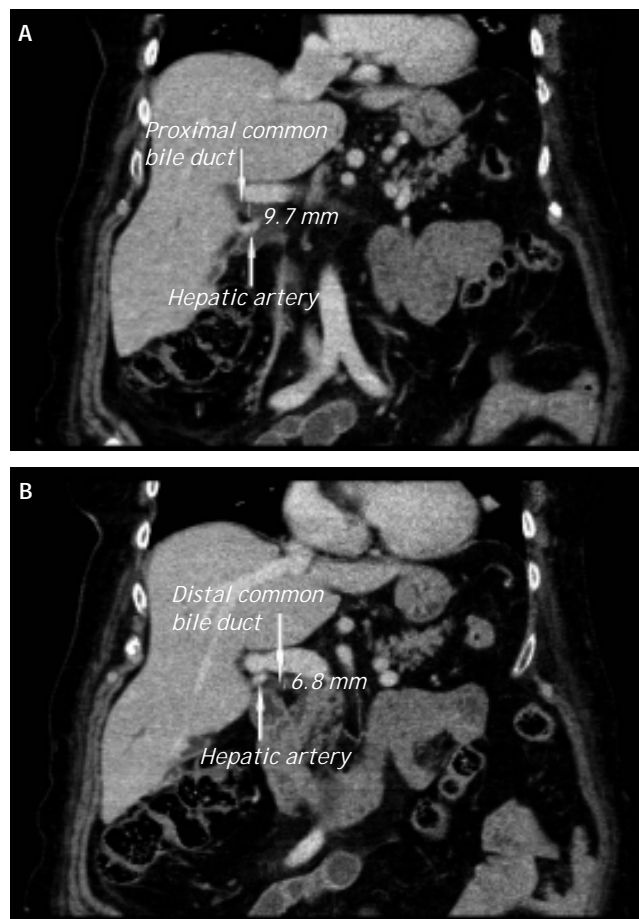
A and B. Abdominal computerized tomography (CT): compression of the extrahepatic bile duct by the right hepatic artery.
